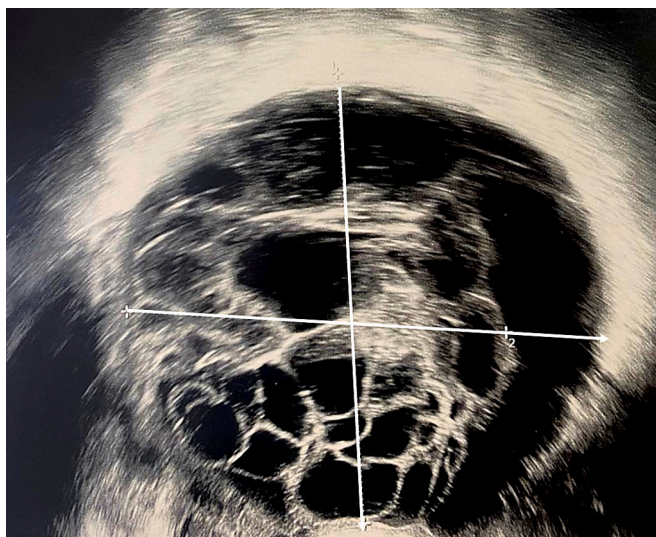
Transvaginal ultrasonography (US) imaging of ovarian cyst at first admission. The US showed a multi-septate cystic mass in the left adnexa, measuring approximately 12 × 12 cm.
